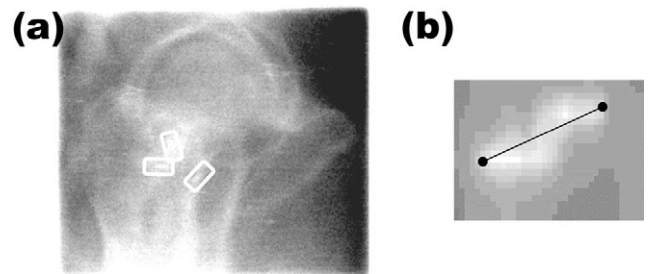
(a) Lateral portal image of a patient with 3 fiducial markers implanted into the prostate. White boxes indicate the position of the fiducial markers that can be hard to visualize in the lateral images due to overlying bony anatomy. (b) Example region of digitally reconstructed radiograph image containing a fiducial marker. The length and orientation of the marker are calculated from the pixel coordinates of the ends of the marker that are identified manually.
